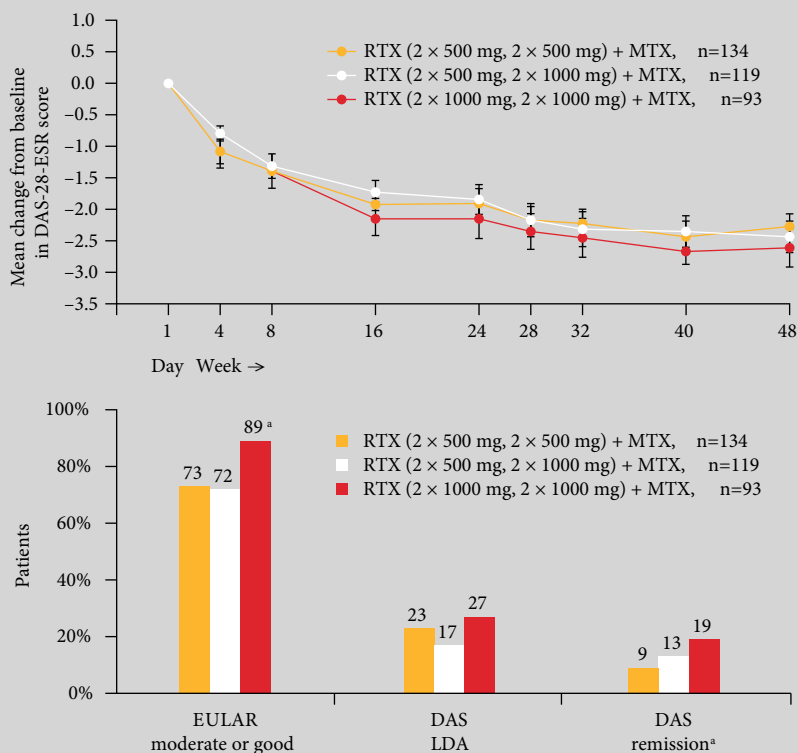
Dose intervals of rituximab (RTX) and methotrexate (MTX). Evidence on dose of rituximab and re-treatment interval is complex. Clinical response rates were numerically better at the 2×1000 mg dose in the DANCER study [12] compared to a 2×500 mg dose, and EULAR response rates were significantly better in MIRROR [14] – both in established rheumatoid arthritis (RA) that is resistant to methotrexate and usually also tumor necrosis factor (TNF)-blocking therapies. The SERENE [15] and IMAGE [16] trials in earlier RA populations did not demonstrate any difference in clinical outcomes between doses in earlier RA populations, although there was a difference in radiographic outcomes. Collectively, these trials indicate that a 2×500 mg dose of rituximab is effective, but there are some advantages to a 2×1000 mg dose, especially in the first cycle of treatment. DAS, disease activity score; ESR, erythrocyte sedimentation rate; EULAR, European League Against Rheumatism; LDA, low disease activity.
